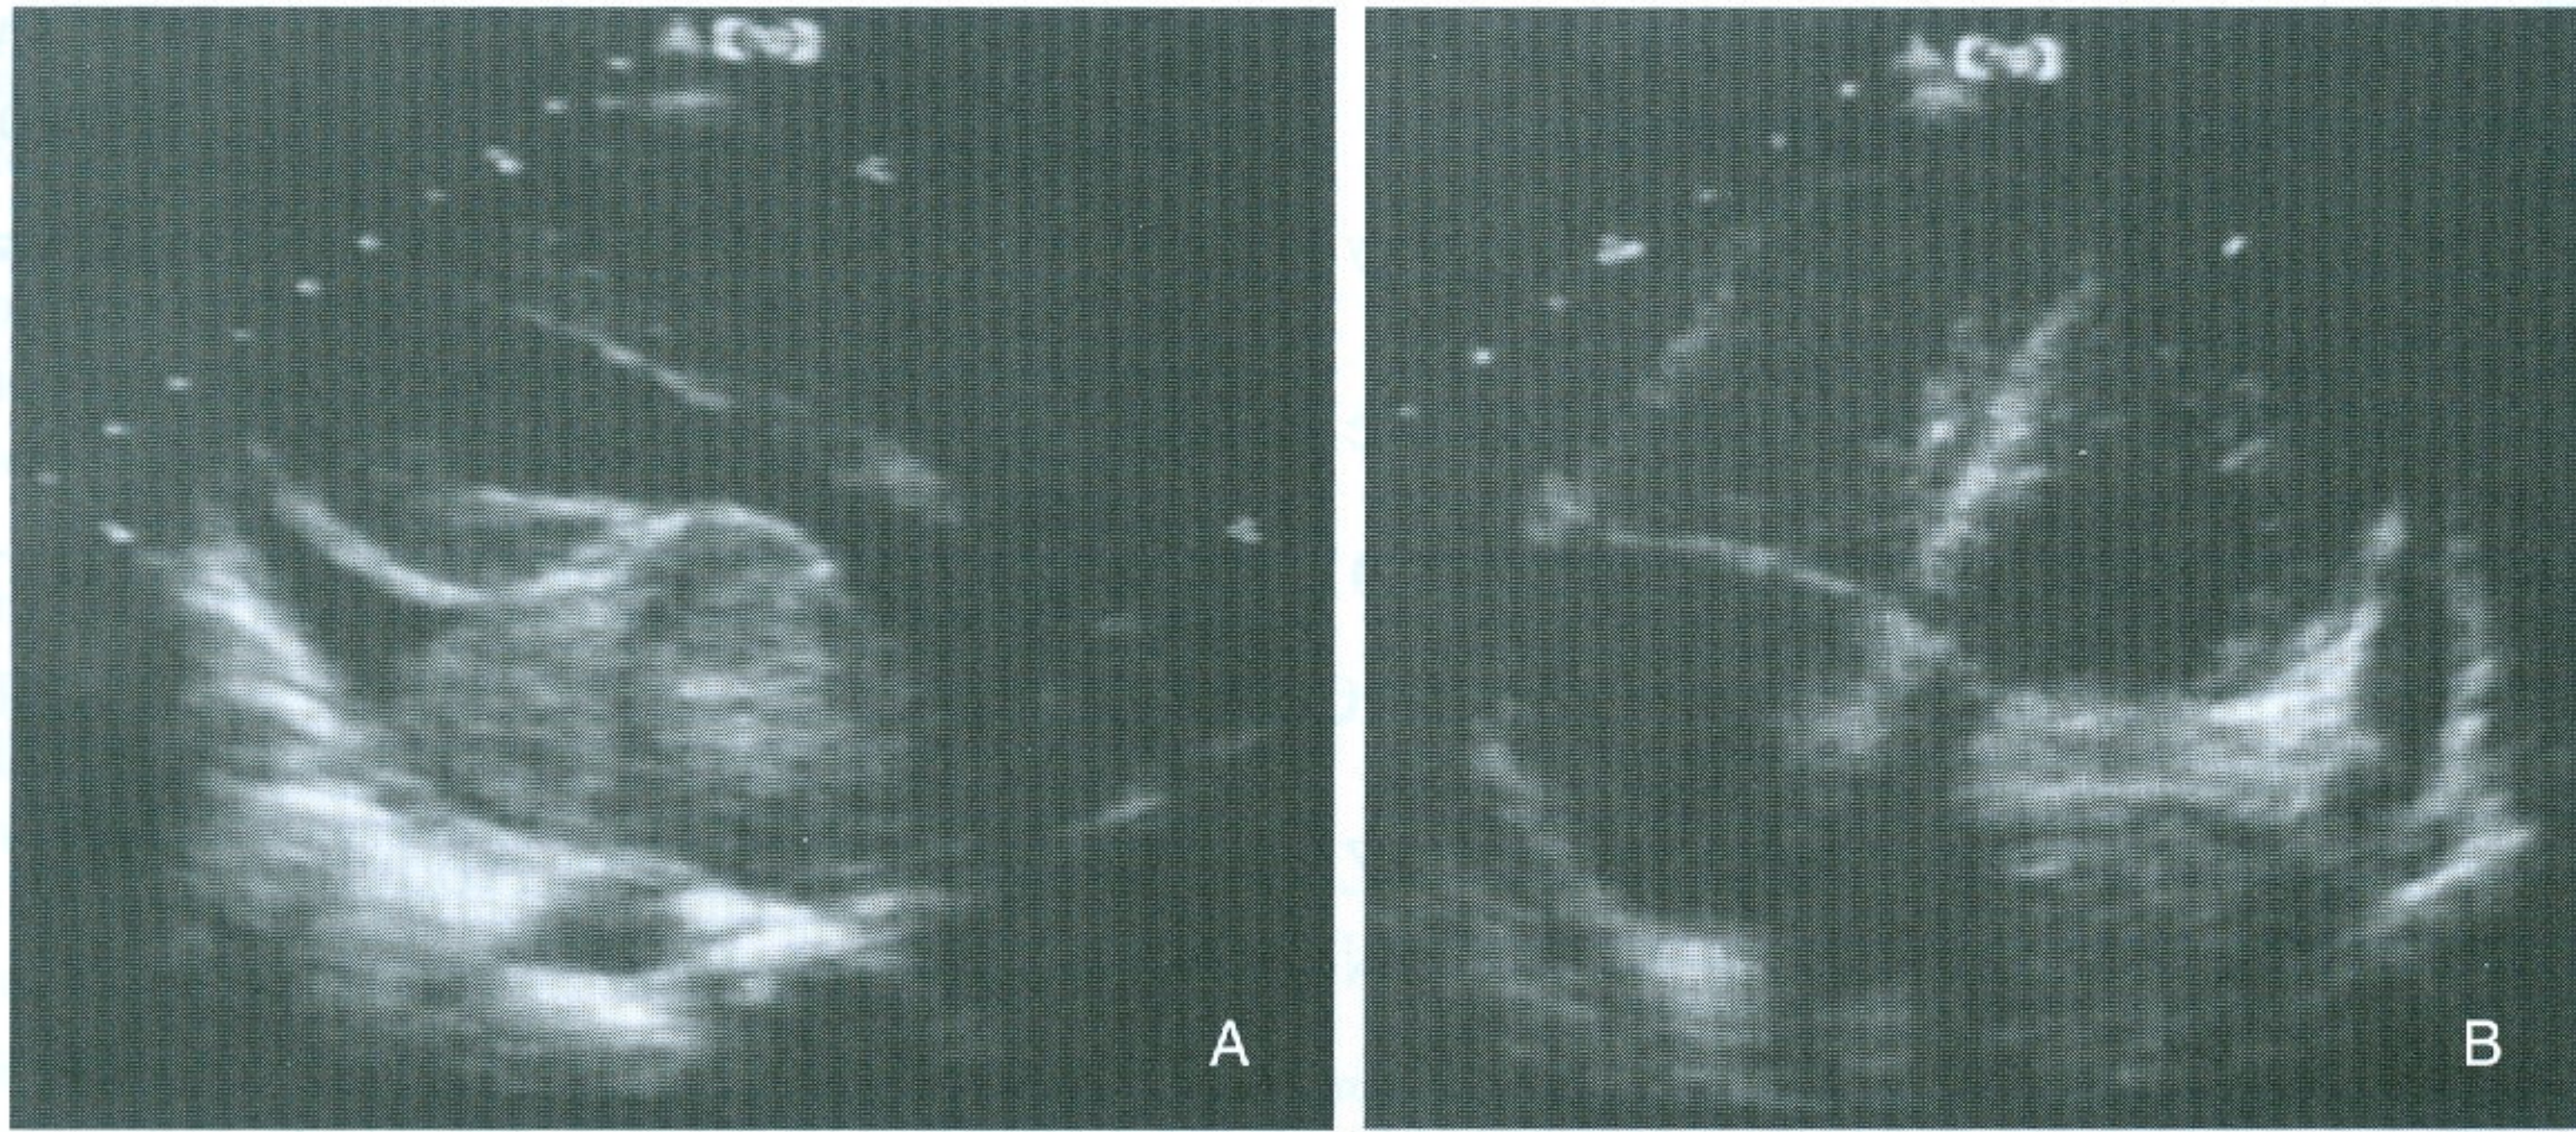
Large intrapericardial mass compressing on the left atrium in the left sternal edge (A) long-axis view and (B) apical four-chamber view.
